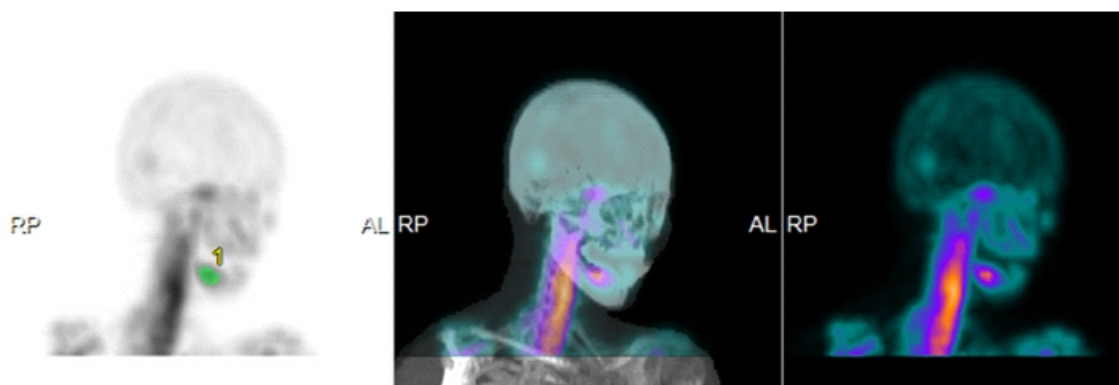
Volume of interest setting method using GI-BONE. Nuclear medicine image (green part is the set VOI) (left). SPECT/CT fusion image (middle). Nuclear medicine image (right).
